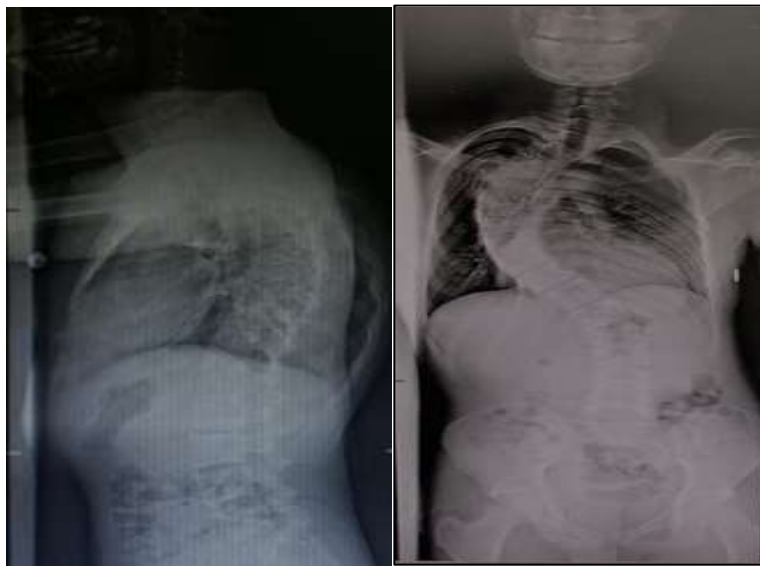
x ray radiograph showing right side thoracic scoliosis.
